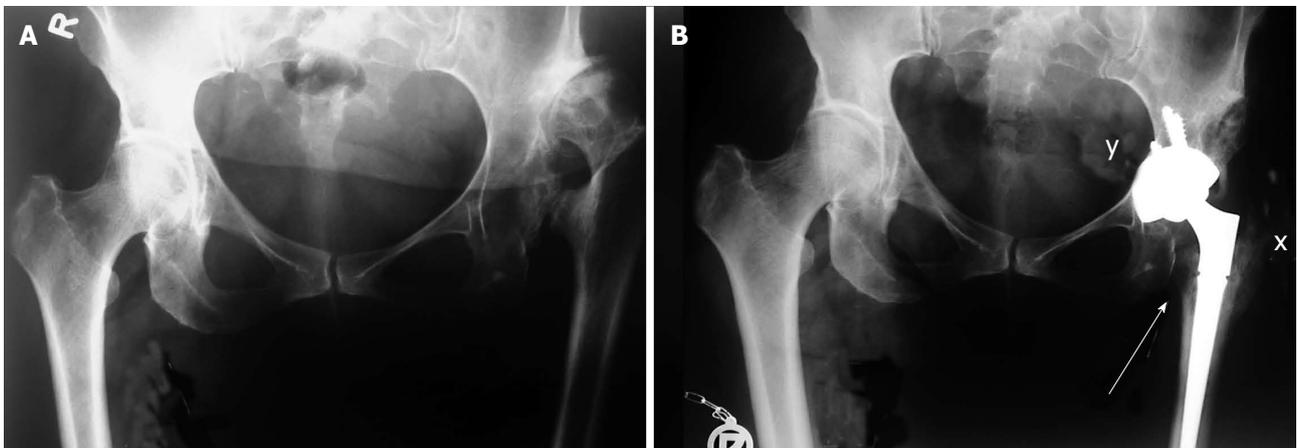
X-rays of patient with Crowe type 4 dysplasia on the left side and normal hip on right side. A: Preoperative X-ray with secondary osteoarthritis due to dysplasia, neoacetabulum formed superolaterally from original, true acetabulum and significant leg length discrepancy; B: Postoperative X-ray with implanted cemented acetabular cup and femoral stem. Acetabular cup is protruding beyond the Kohler's line inside the pelvis (marked with y) and secured with 3 additional screws. Lesser trochanter is brought distally to the normal level so there is no leg length discrepancy postoperatively (marked with a single arrow). Modified direct lateral approach was used and posterior part of the gluteus medius and vastus lateralis together with the external rotators were detached with the chisel on a thin flake of bone, now they are completely attached and healed to greater trochanter (marked with x).
